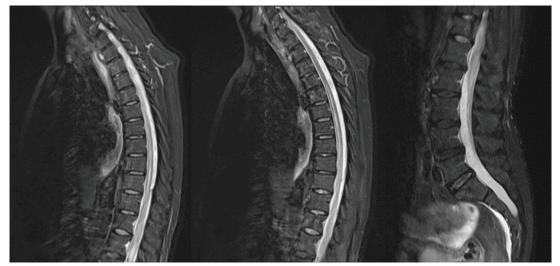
Dorsolumbosacral MRI without contrast showing an extensive area of hypersignal in T2-weighted sequences, from planes posterior to the D5-D6 intersomatic disc to the medullary cone, with a predominantly centro-medullary pattern of involvement, with no obvious association with anomalous vascular structures within the spinal canal.
